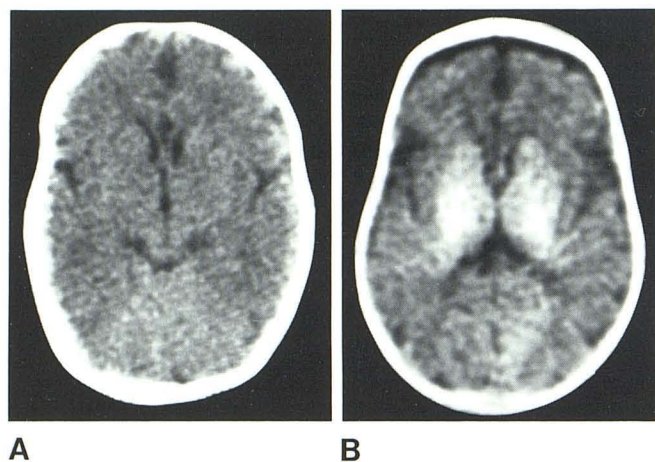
CT (A) and IR_{1400/400} (B) scans in 7-week-old infant. White matter seen only in central regions of brain.
